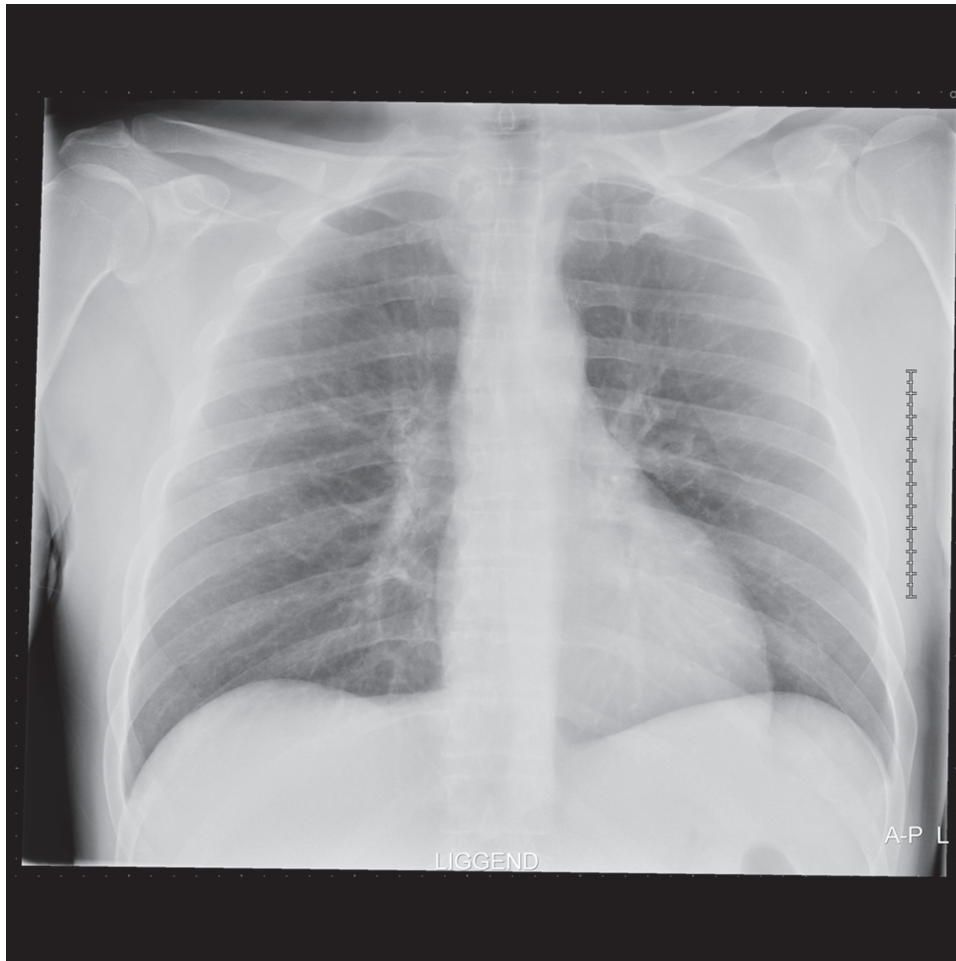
Radiograph on admission, showing subtle bilateral opacifications.
